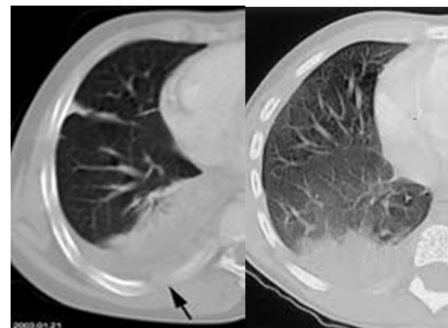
Examples of CT scan of PE
